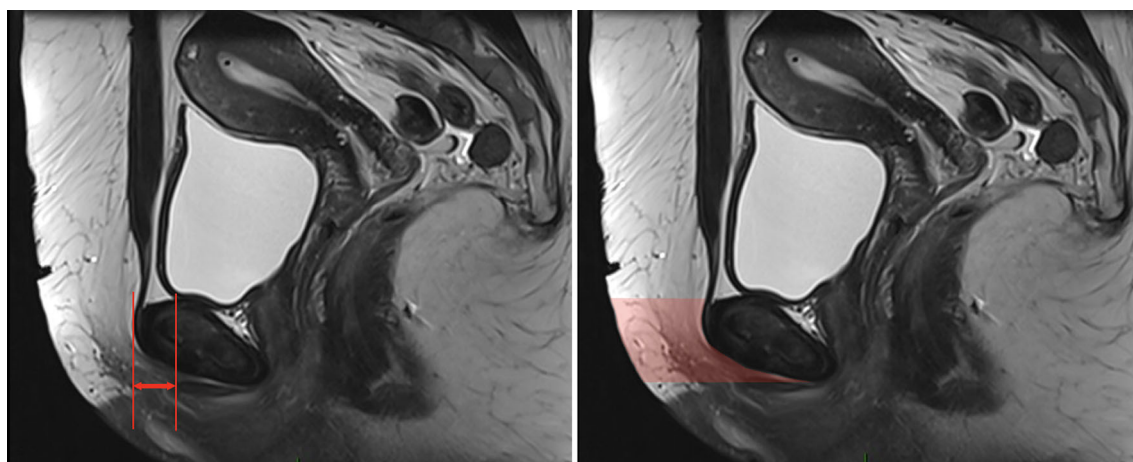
MRI analysis of the clitoris (CP distance on the left) and the prepubic fat surface (PP surface on the right)
